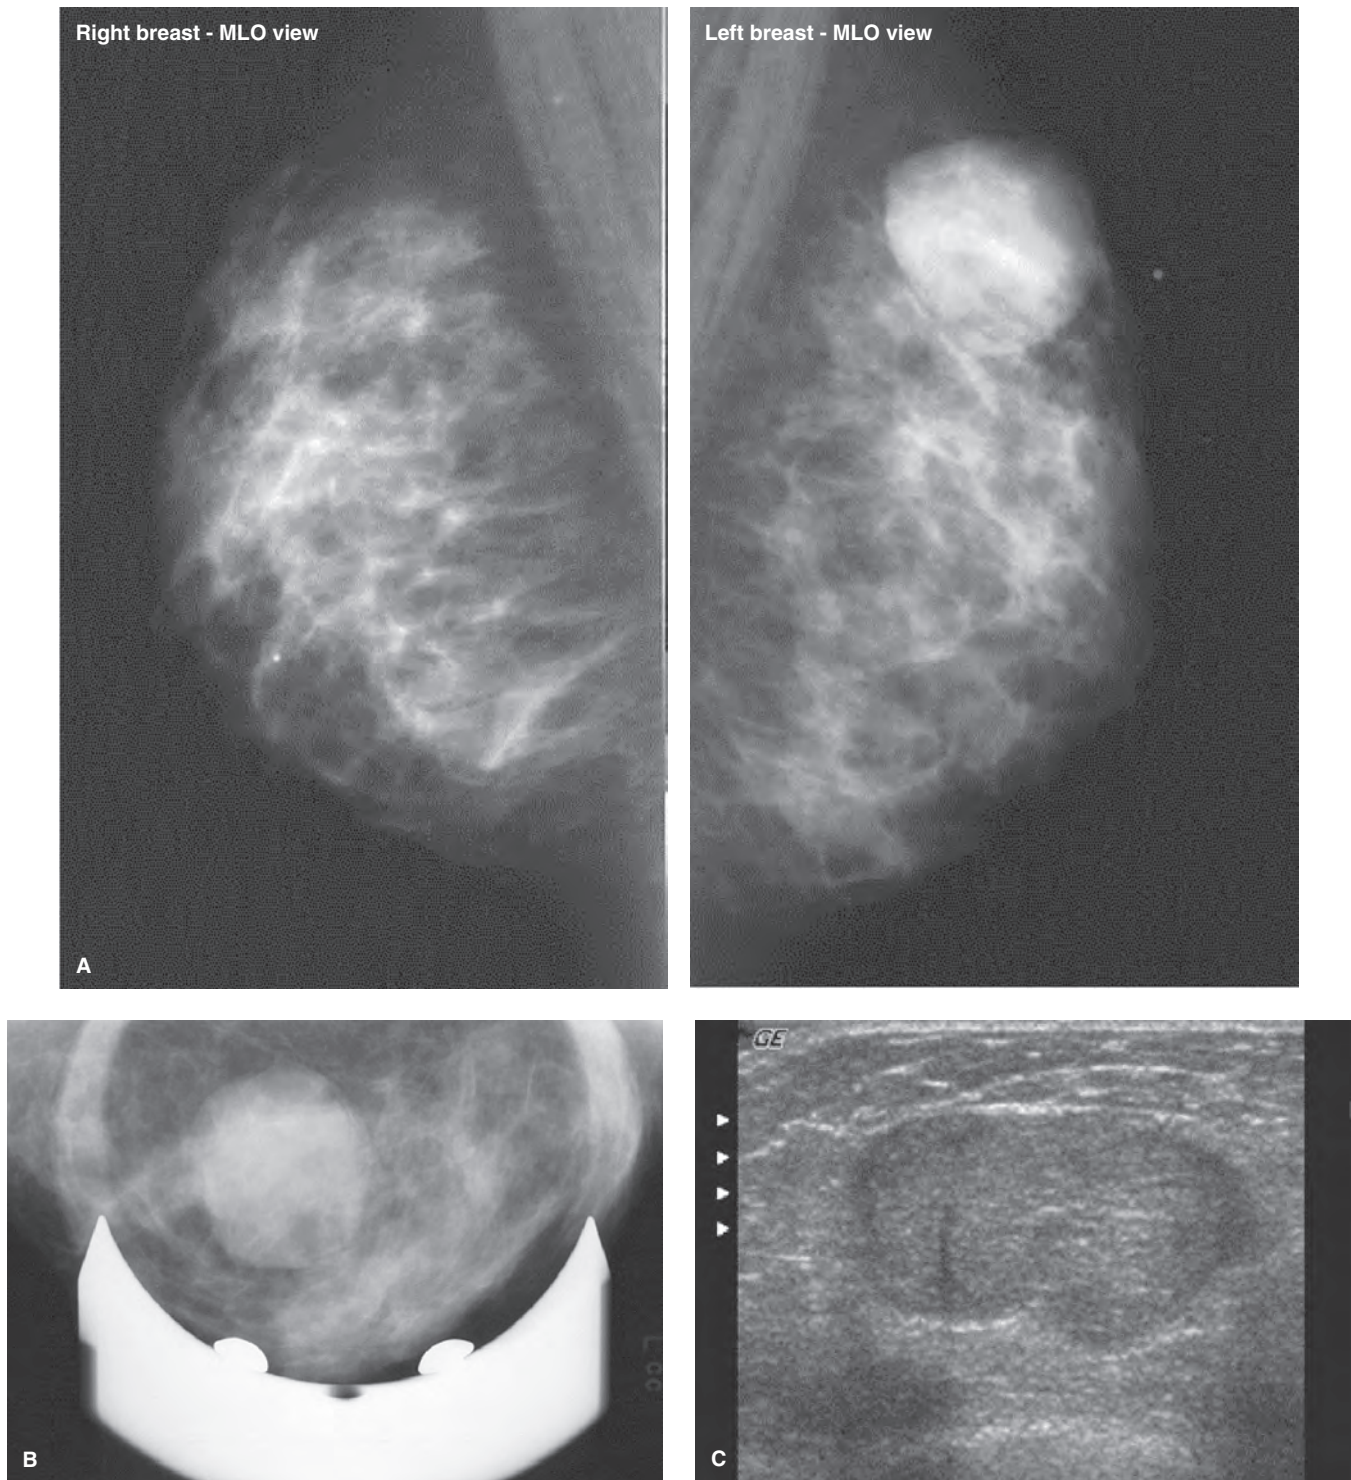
Standard imaging studies of a phyllodes tumor. (A) Bilateral mammogram, MLO view, demonstrating circumscribed round mass at 12 o'clock in left breast, biopsy proven phyllodes tumor. (B) Spot compression mammographic view of phyllodes tumor from (A). (C) Ultrasound image of a 2.4-cm phyllodes tumor, showing typical sonographic features including oval shaped solid mass with circumscribed margins.
